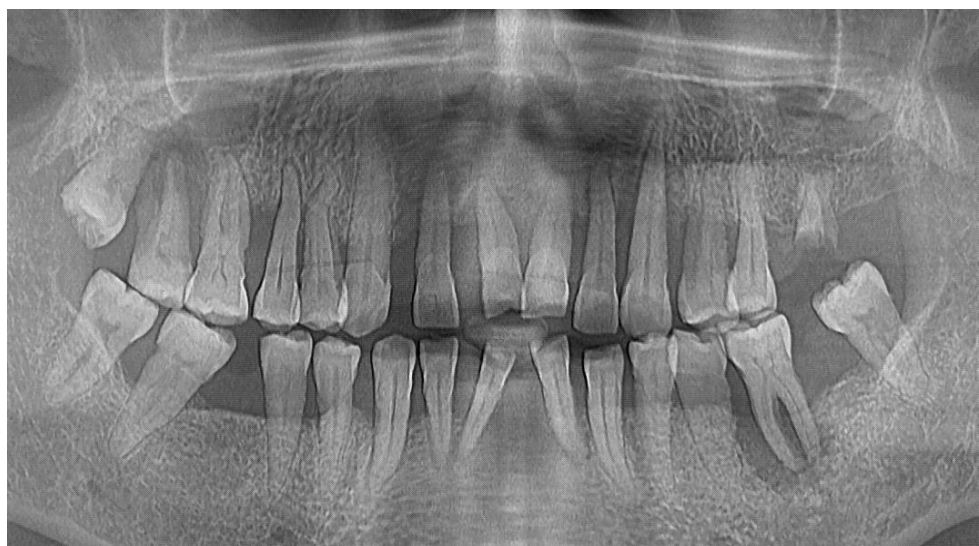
Orthopantomogram - initial status
